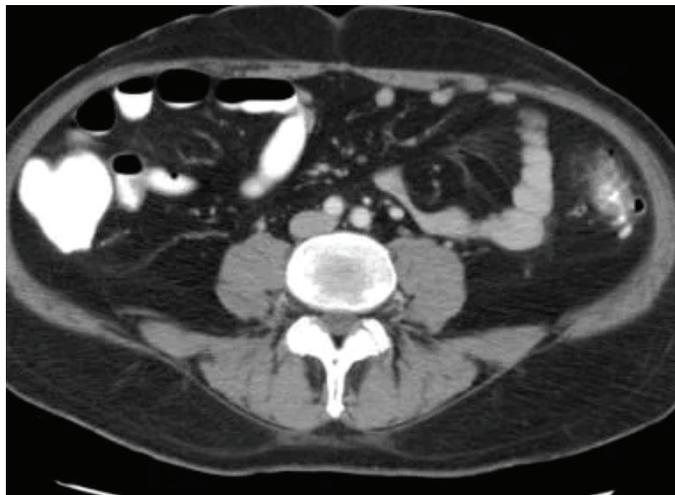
Diverticulitis on computed tomography
